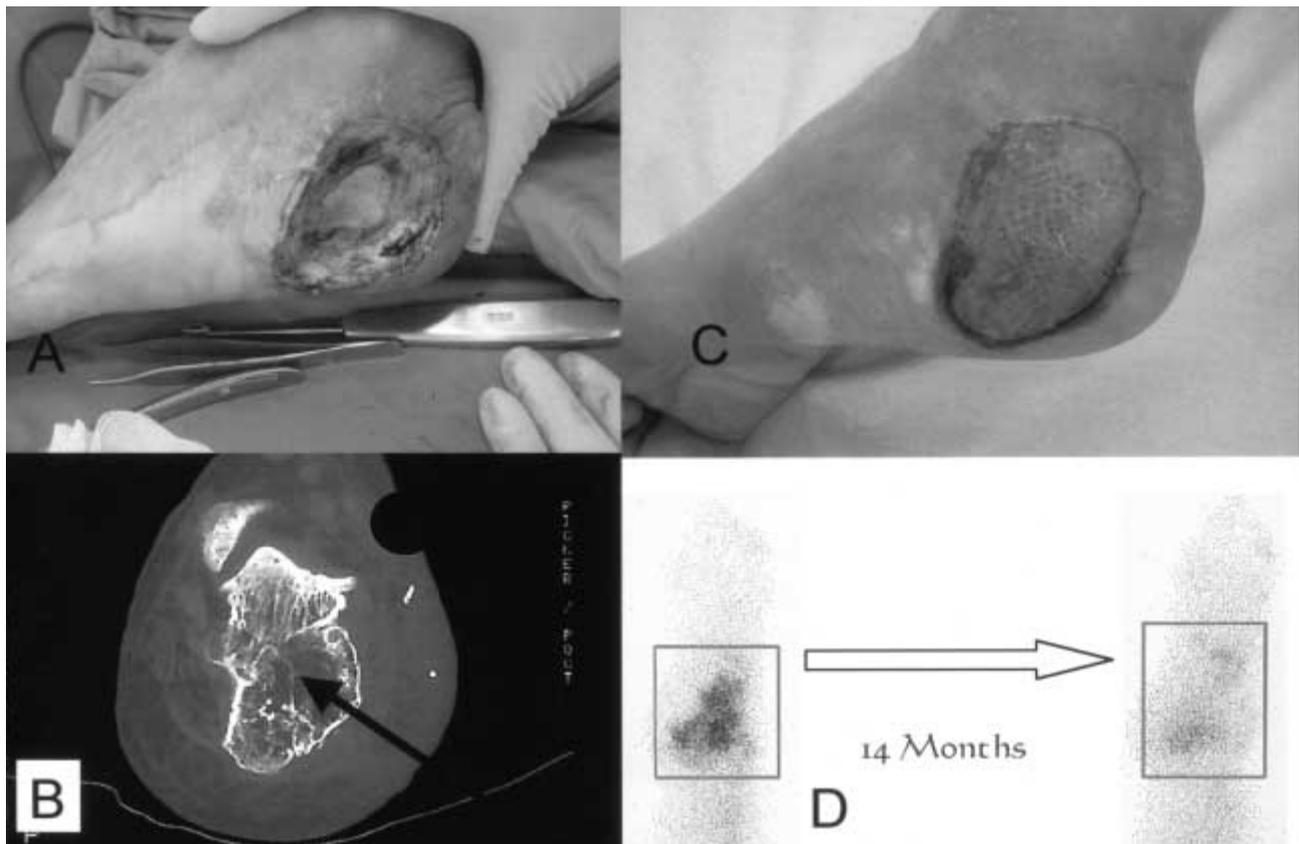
Osteomyelitis of the calcaneal bone. Peroperative view after debridement (A). Preoperative osteolysis, diagnosed by CT (B). Early postoperative view (4 months) after free serratus anterior muscle transfer (C). Almost complete removal of the hot spot after 14 months on leucocytes scanning (D).
